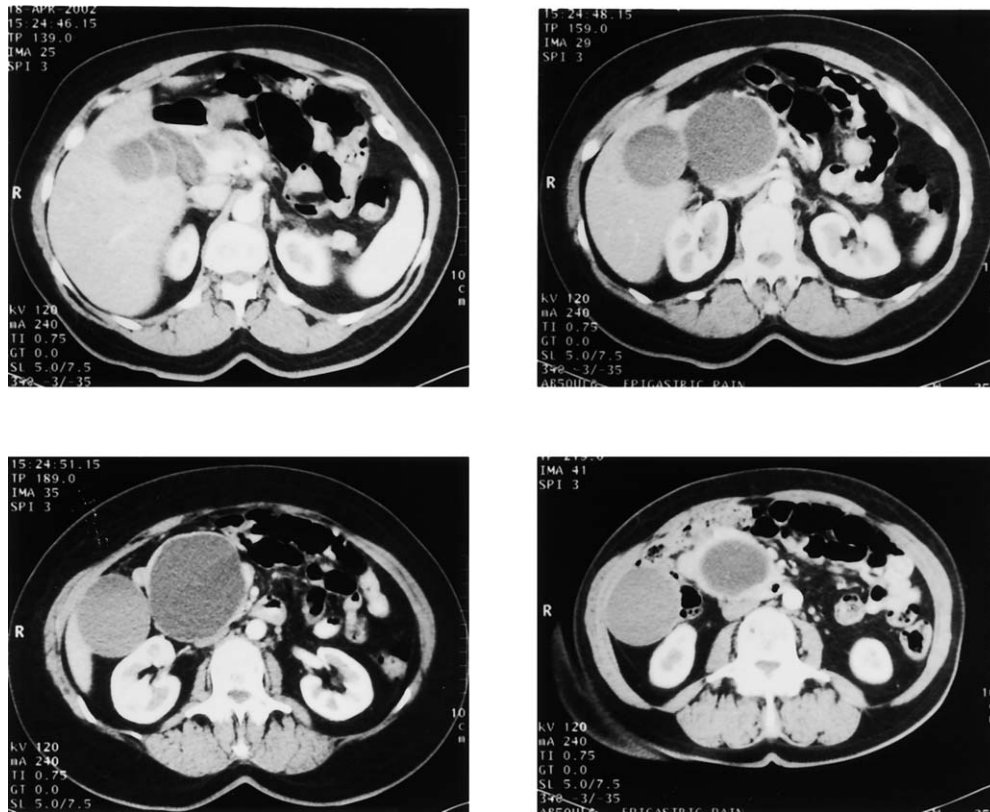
Series of abdominal CT images with both oral and intravenous contrast revealing a large gallbladder and an 8 cm cystic lesion. The lesion extends from the hepatic hilum (*top left*) inferiorly to the point where it is surrounded by pancreatic parenchyma (*bottom right*).
